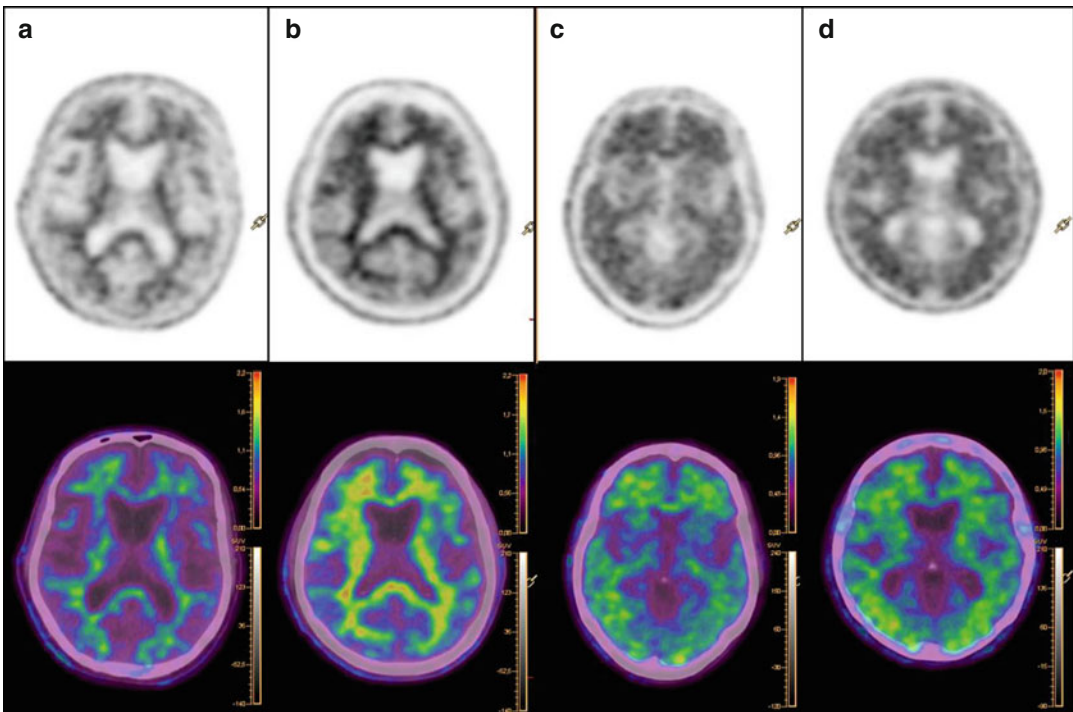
Images of 18F-florbetapir PET (top row) and PET-CT (down row). Negative amyloid PET in healthy control (a) and in MCI patient (b) with a contrast between white and gray matter. Positive amyloid PET in MCI (c) and AD (d) patients with high cortical retention of tracer reflecting amyloid deposition
